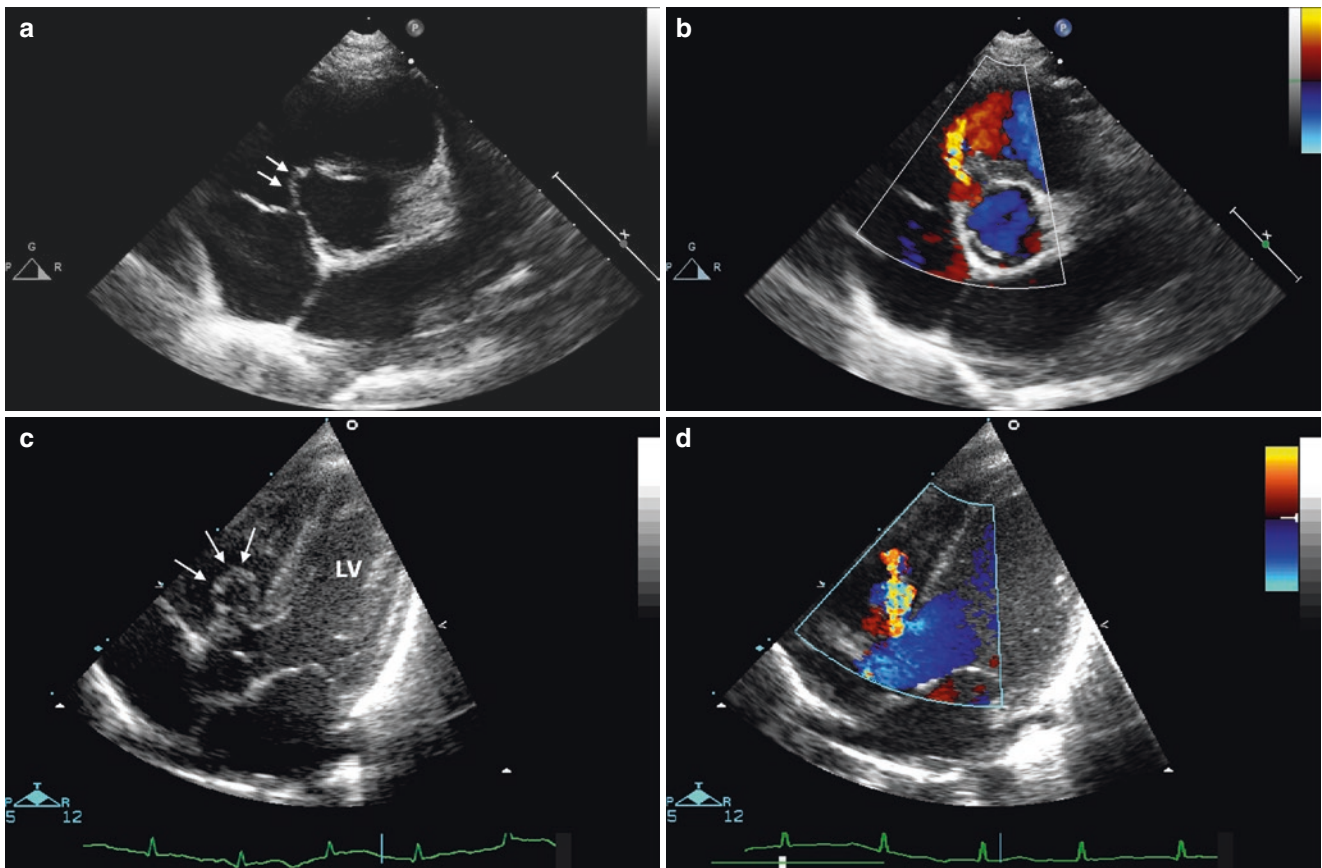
Parasternal short-axis view showing restriction of a perimembranous VSD (*arrows*) due to accessory tricuspid valve tissue (*a*). Colour Doppler confirms a small amount of LR-shunting (*b*).
